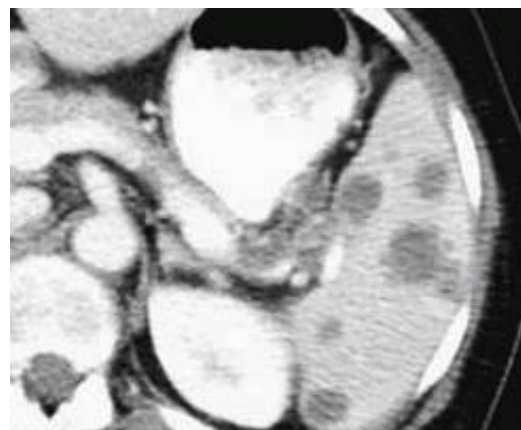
CT scan of abdomen showing hypodense lesions in Spleen
